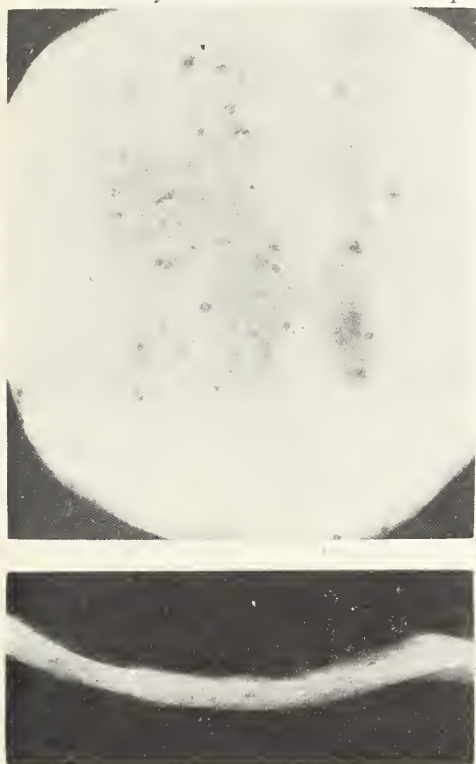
X-rays of the skull plate and rib showing small circumscribed lesions in the former and a coarse trabecular appearance of the latter without evidence of areas of destruction. Both are reproductions of films taken postmortem.
